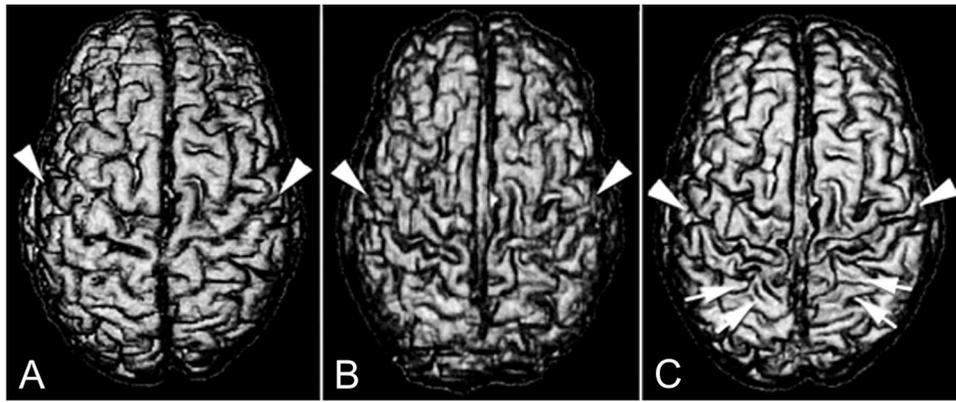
Rendered volumes as viewed from above from three-dimensional MRI at baseline (A), 4.7 years (B), and 8.5 years (C) after the baseline scan. Note progressive loss of the paracentral cortex (central sulcus marked by arrowheads). In the most recent scan, atrophy of the superior parietal region has become apparent (C, double arrows). Adapted with permission from Smith (20).
